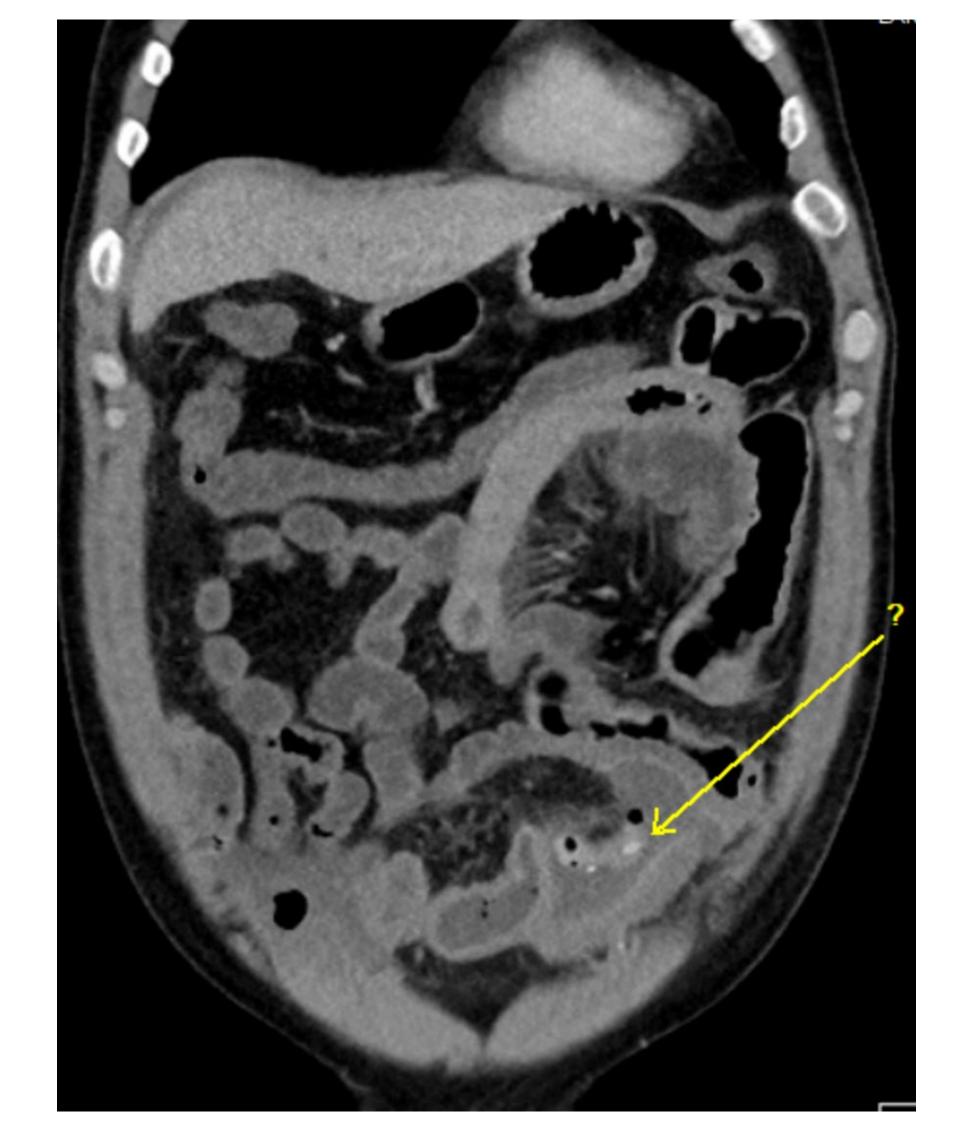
CT scan of the abdomen and pelvis demonstrated a mildly distended small bowel loop in the left anterior abdomen with an adjacent surgical staple line contiguous with a small tubular density filled with air and a single calcification.
